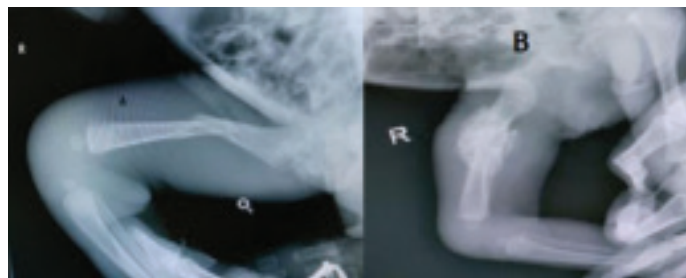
(2A) Lateral radiograph showing oblique fracture of the right femoral shaft (lower extremity), (2B) Control radiograph at 6 weeks; adequate callus tissue is visible
